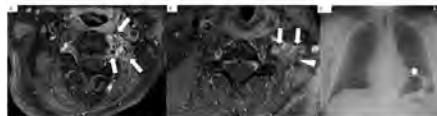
Axial neck MRI with contrast of a 71-year-old female patient presenting with left axillary shoulder girdle and displaced clavicle metastatic structures in situ in the left posterior triangle (arrow), giving rise to three enhancing branches. These findings are consistent with perineural tumor spread along the superficial nerve, involving its three distal branches: the medial, paramedian and lateral supraclavicular nerve.
